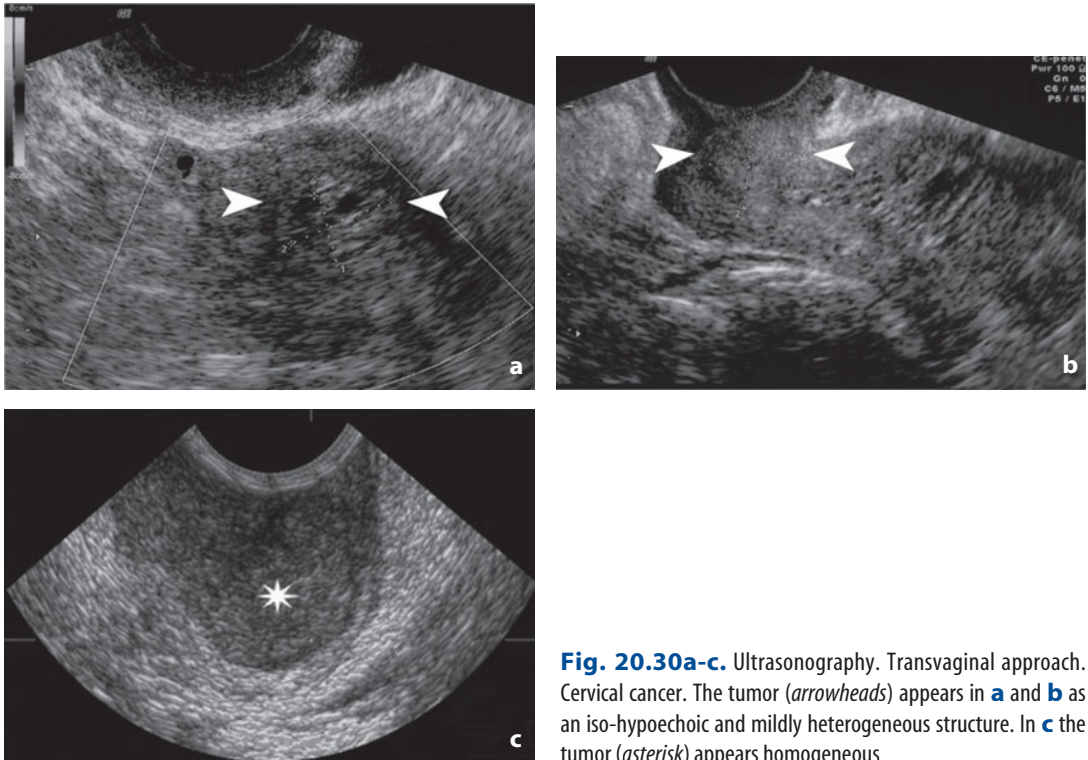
Ultrasonography. Transvaginal approach. Cervical cancer. The tumor (*arrowheads*) appears in a and b as an iso-hypoechoic and mildly heterogeneous structure. In c the tumor (*asterisk*) appears homogeneous
